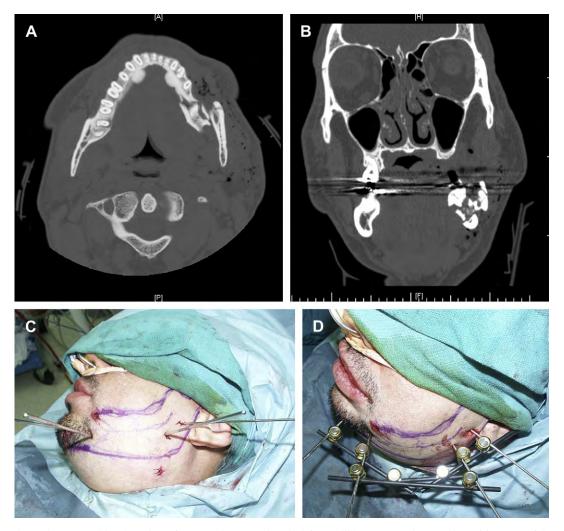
A 29-year-old male patient after a gunshot wound to the left mandible. (*A*) Note the comminuted fractures of the mandibular body on the axial CT image. (*B*) Coronal CT shows multiple fragments involving the left mandible. (*C*) Skin markings and identification of the fractures are accomplished. Drill bits are inserted through a stab incision and trochar. Two pins are placed at least 10 mm from the fracture, 25 mm apart. (*D*) Pins on the same side of the fracture are joined together with one or two rods. Each set of pins is then linked across the fracture with additional rods. (*E*) Postoperative posterior-anterior cephalogram shows pin placement and reduction of mandibular fragments. (*F*) Panoramic radiograph shows consolidation of the fracture 8 weeks after external fixation. (*G*) Definitive treatment consisted of debridement of the area, bone graft, and reconstruction of the defect.
